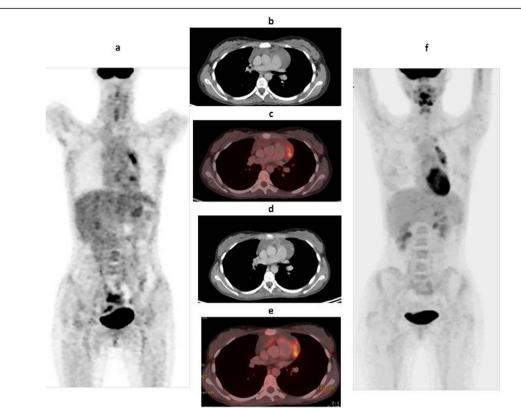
A 20-year-old female patient, recently diagnosed case of HL. Initial PET/CT study revealed hypermetabolic mediastinal mass in whole body PET MIP image (a), formed of enlarged amalgamated retrosternal/prevascular mediastinal in axial CECT image (b) and achieving 5.5 SUL_{peak} in corresponding fused PET/CT image (c). Follow-up PET/CT study still showed the hypermetabolic mediastinal mass in whole body PET MIP image (f) that was of stationary size in axial CECT image (d) denoting SD according to RECIST 1.1, and almost showing stationary FDG uptake (6 SUL_{peak}) in fused PET/CT image (e) denoting SMR according to PERCIST 1.0
